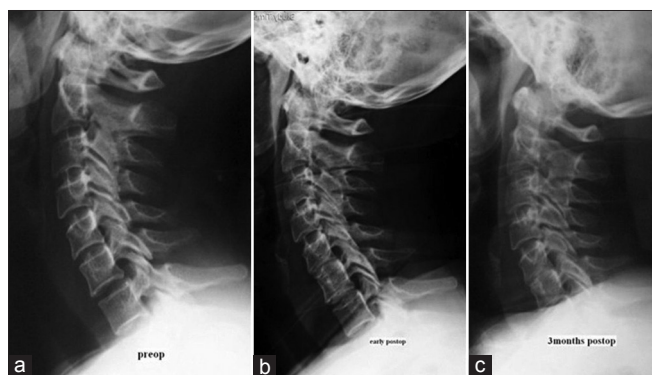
(a) Preoperative, (b) Early postoperative and (c) 3 months postoperative X-ray images of a patient submitted to C5-C6 interbody fusion. The spine alignment is maintained following operation. Fusion is eventually obtained
